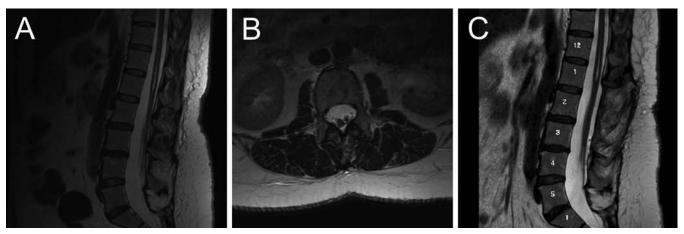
A and B: Preoperative sagittal and axial T2-weighted MR images showing a tethered cord and T12–L1 syrinx (A) and diastematomyelia (B). C: Postoperative sagittal T2-weighted image with fat suppression showing the complete L-2 laminectomy and detethered cord.
